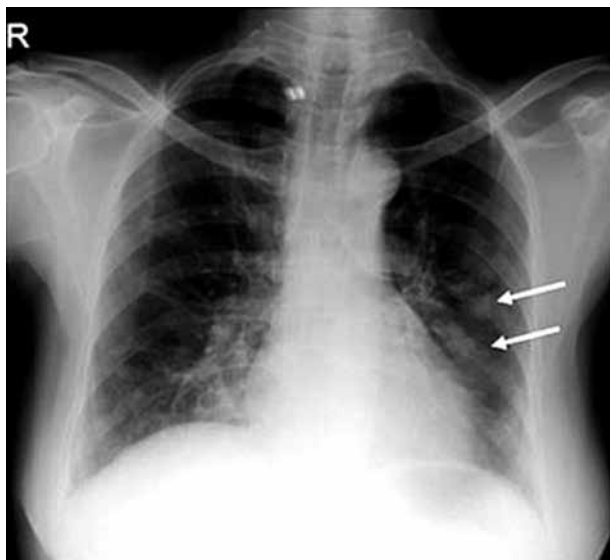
Chest X-ray of non-tuberculous mycobacteria diagnosis: consolidation and fibrosis in medium lobe of the lung (white arrow). A) Barcode number: 124475 and B) 120143
